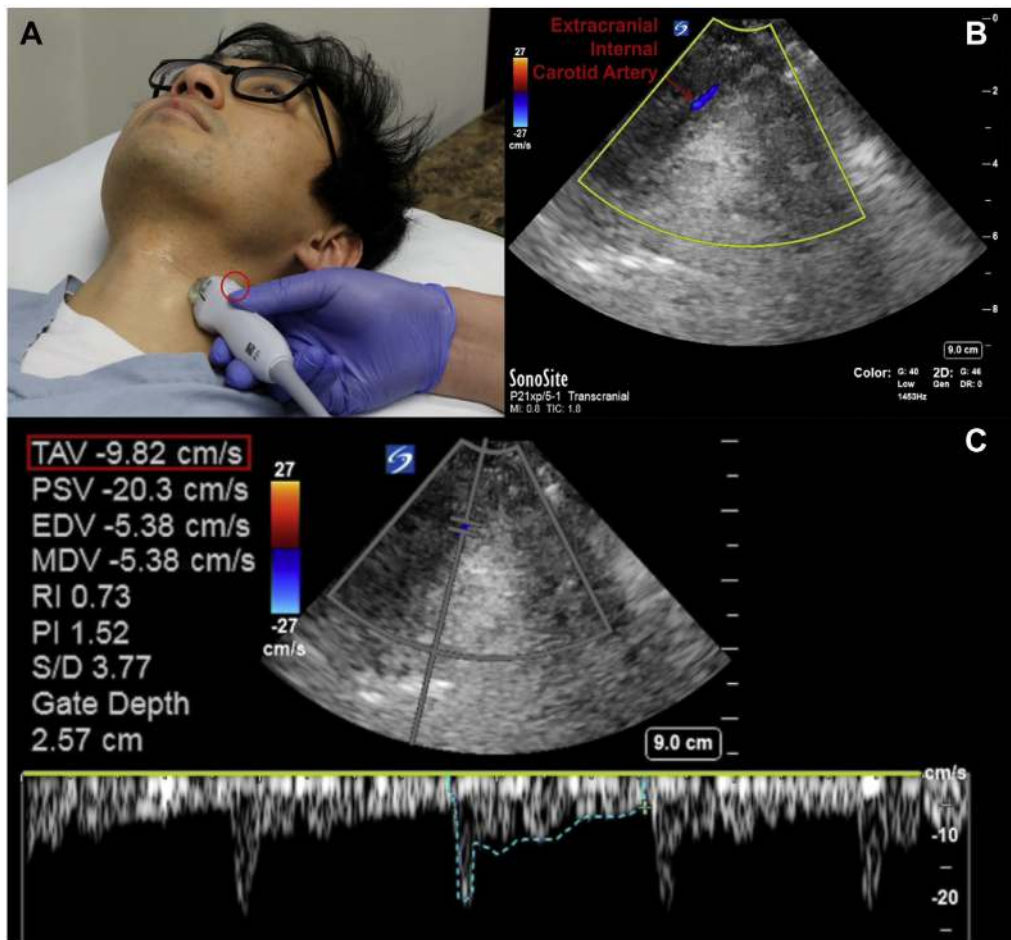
A-C, Detecting and quantifying vasospasm. A, The transducer position to measure velocity in the internal carotid artery. B, Color Doppler reveals the position of the internal carotid artery, with good alignment to measure the velocity from a parallel plane. C, Interrogation of the internal carotid artery with pulsed-wave Doppler and the resulting waveform. The machine software automatically calculates the TAV (also known as mean velocity). EDV = end-diastolic velocity; MDV = mean diastolic velocity; PI = pulsatility index; PSV = peak systolic velocity; RI = resistive index; S/D = systolic/diastolic ratio; TAV = time-averaged velocity.
